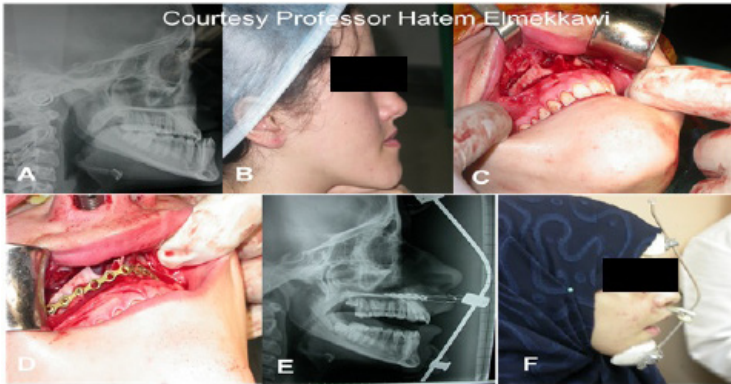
Maxillary advancement A. Pre-operative radiograph. B clinical picture showing flat facial profile. C. Incision and LeFort 1 osteotomy. D Plates attached to the down fractured maxilla. E. radiograph showing the maxillary advancement with facemask in place. E. post-operative picture showing the improvement of facial profile.
